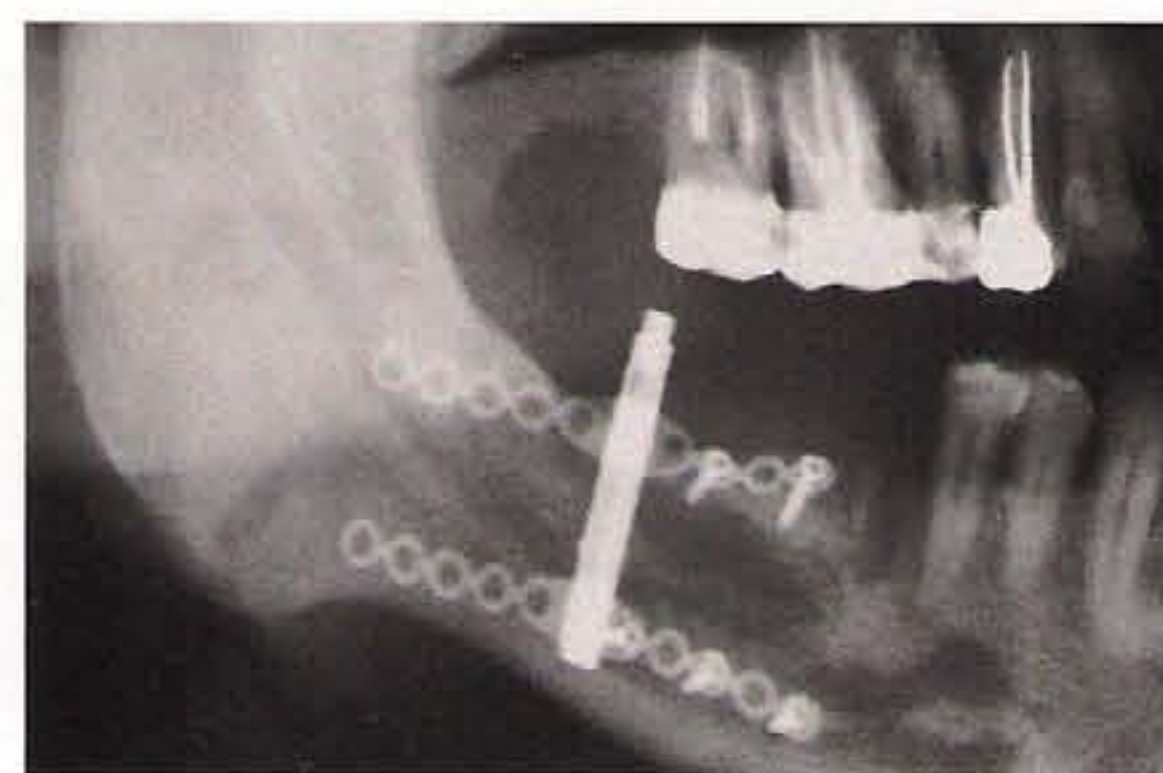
A panoramic radiograph taken 3 months after distraction reveals the mineralization of the distracted bone.
